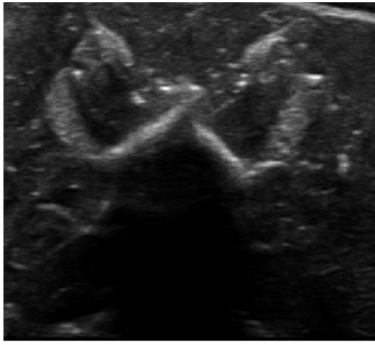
a) Ultrasound image of the intact rabbit's posterior arch. b) Detection of the vertebral surface from our proposed spine surface segmentation algorithm.
